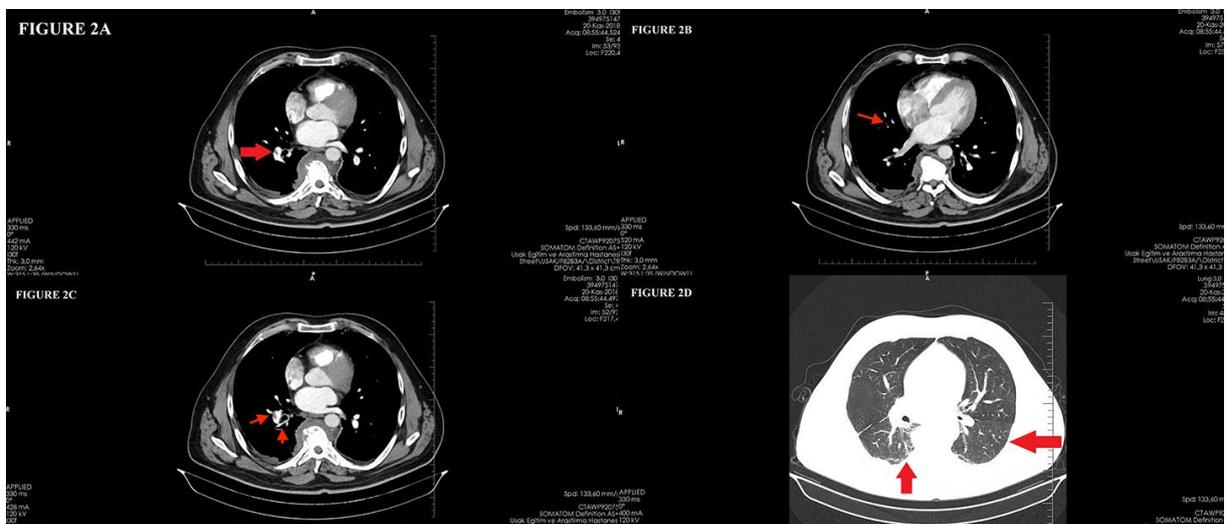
CTA scan shows an eccentrically located thrombus that forms obtuse angles with the vessel wall (arrow)
